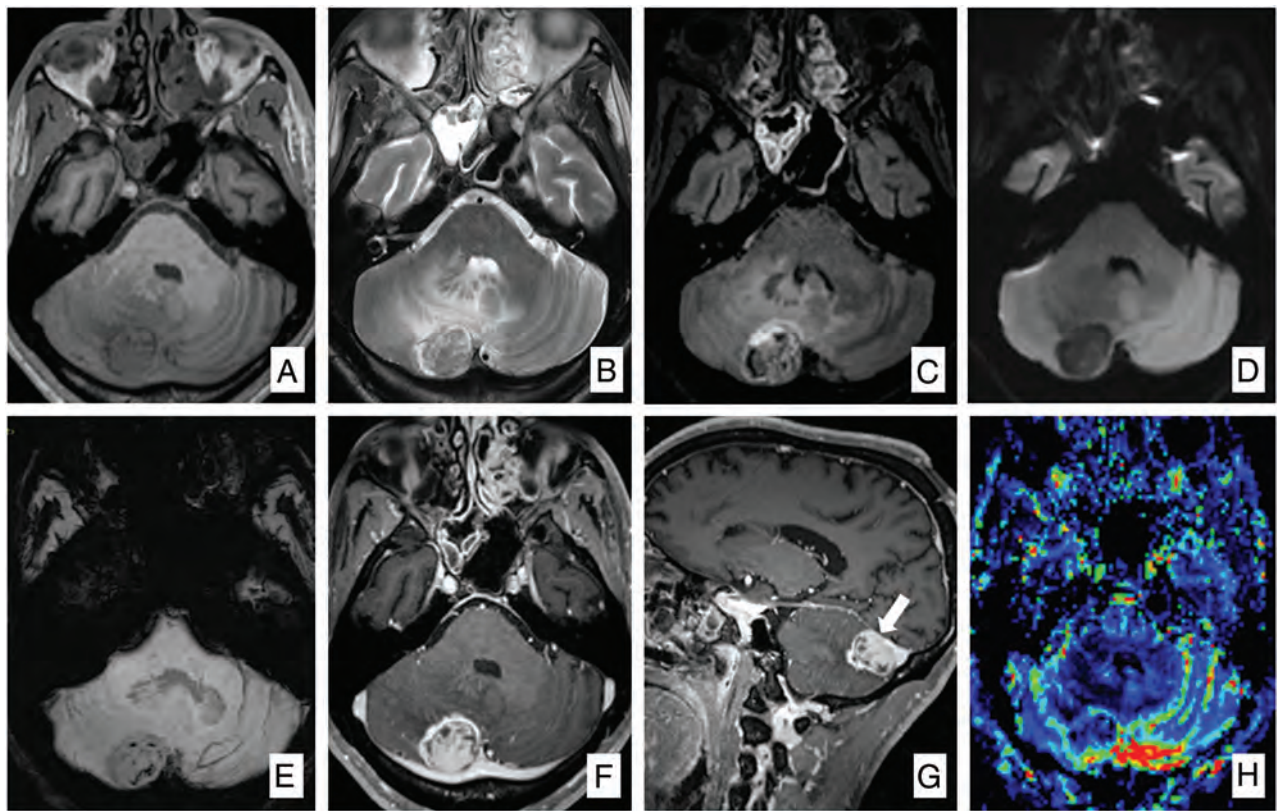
Tumor appearance on MR imaging. MR images show a right posterior fossa mass, which had isointense signal on pregadolinium T1WI (A) and hypointense signal on T2WI (B) and FLAIR (C) with perilesional edema (B and C). The mass does not show diffusion restriction on DWI (D). There are a few blooming foci within the tumor seen on SWI (E). The mass shows intense enhancement with multifocal, small, nonenhancing areas of necrosis on axial postgadolinium T1WI (F). Sagittal postgadolinium T1WI (G) demonstrates the tumor attached to the inferior surface of the right tentorium cerebelli (arrow). On DSC MR perfusion (H), the tumor had low rCBV.
